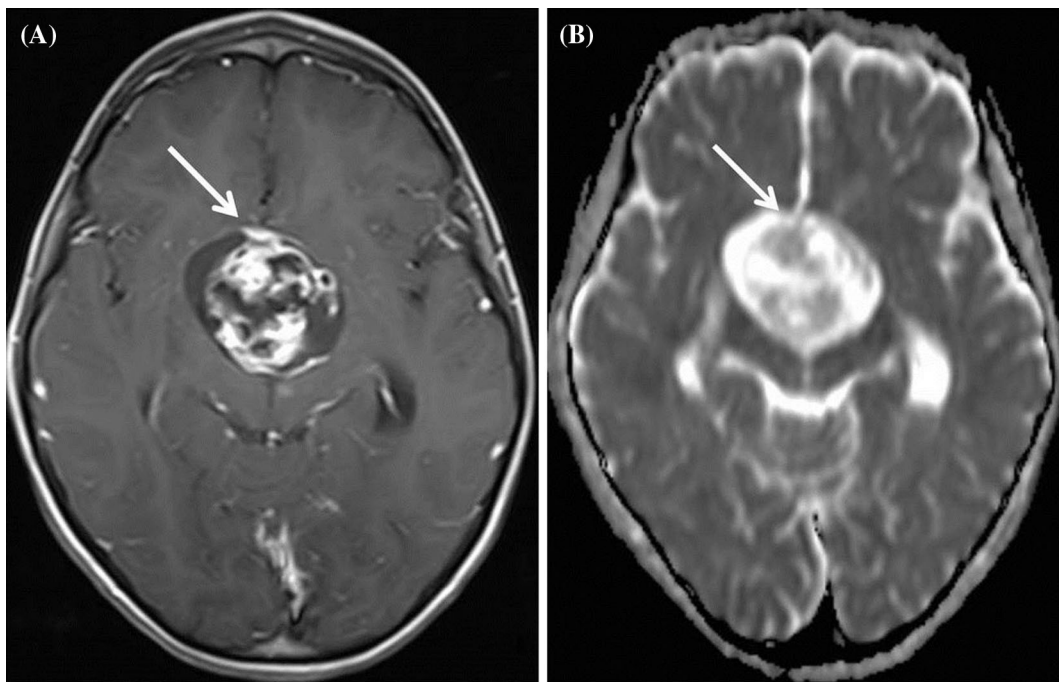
Magnetic resonance (MR) imaging from a 5-year-old girl with immature teratoma. Axial T1-weighted postcontrast (a) and apparent diffusion coefficient (ADC) images showed heterogeneously
